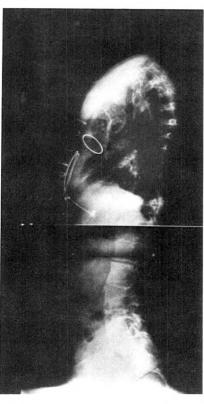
Posterior-anterior and lateral x-ray views of the chest and the lumbar spine.
